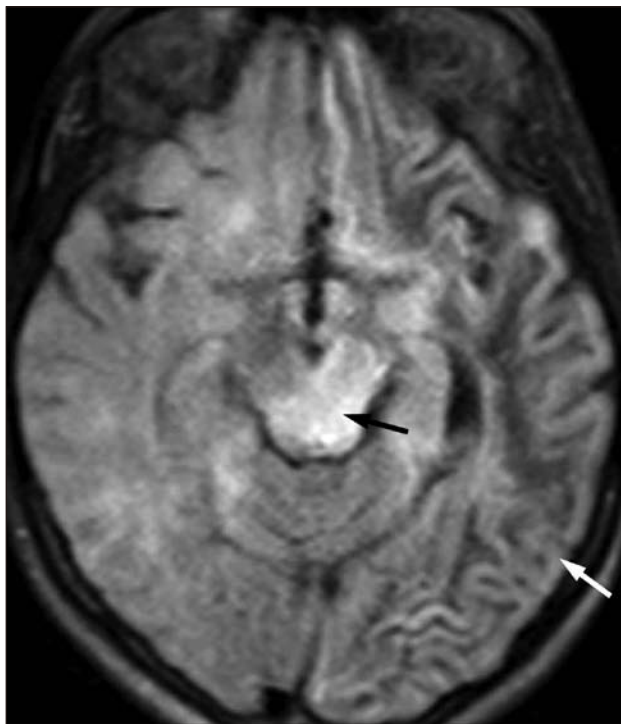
Follow-up axial fluid attenuated inversion recovery magnetic resonance image at 4 months showing T2 hyperintensity of the brainstem (black arrow) indicating severe demyelination. There was left cerebral atrophy (white arrow).
